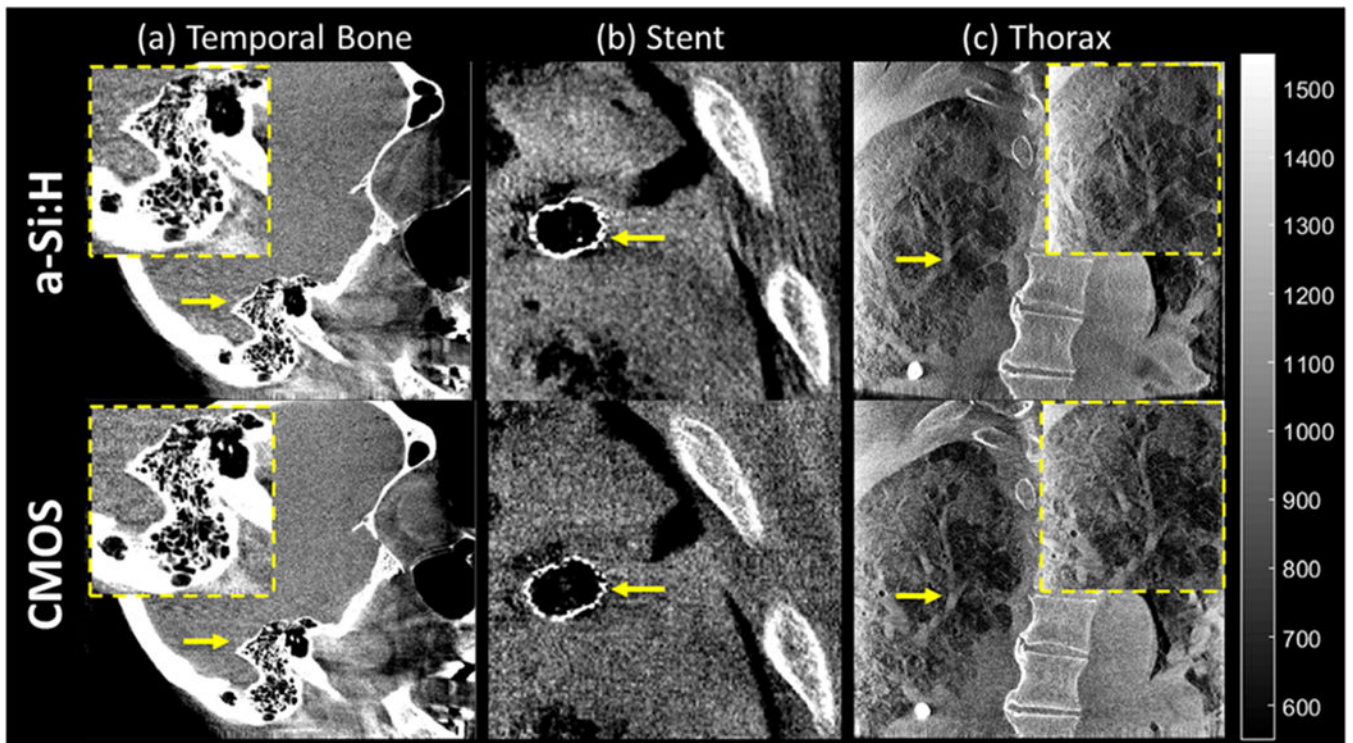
CBCT images (100 kVp, 500 images/333° arc, ~3-4 mGy CTDI_w) of (a) temporal bone, (b) stent implant, and (c) thoracic cavity reconstructed with the “Sharp” protocol for visualization of high-contrast, fine details.
